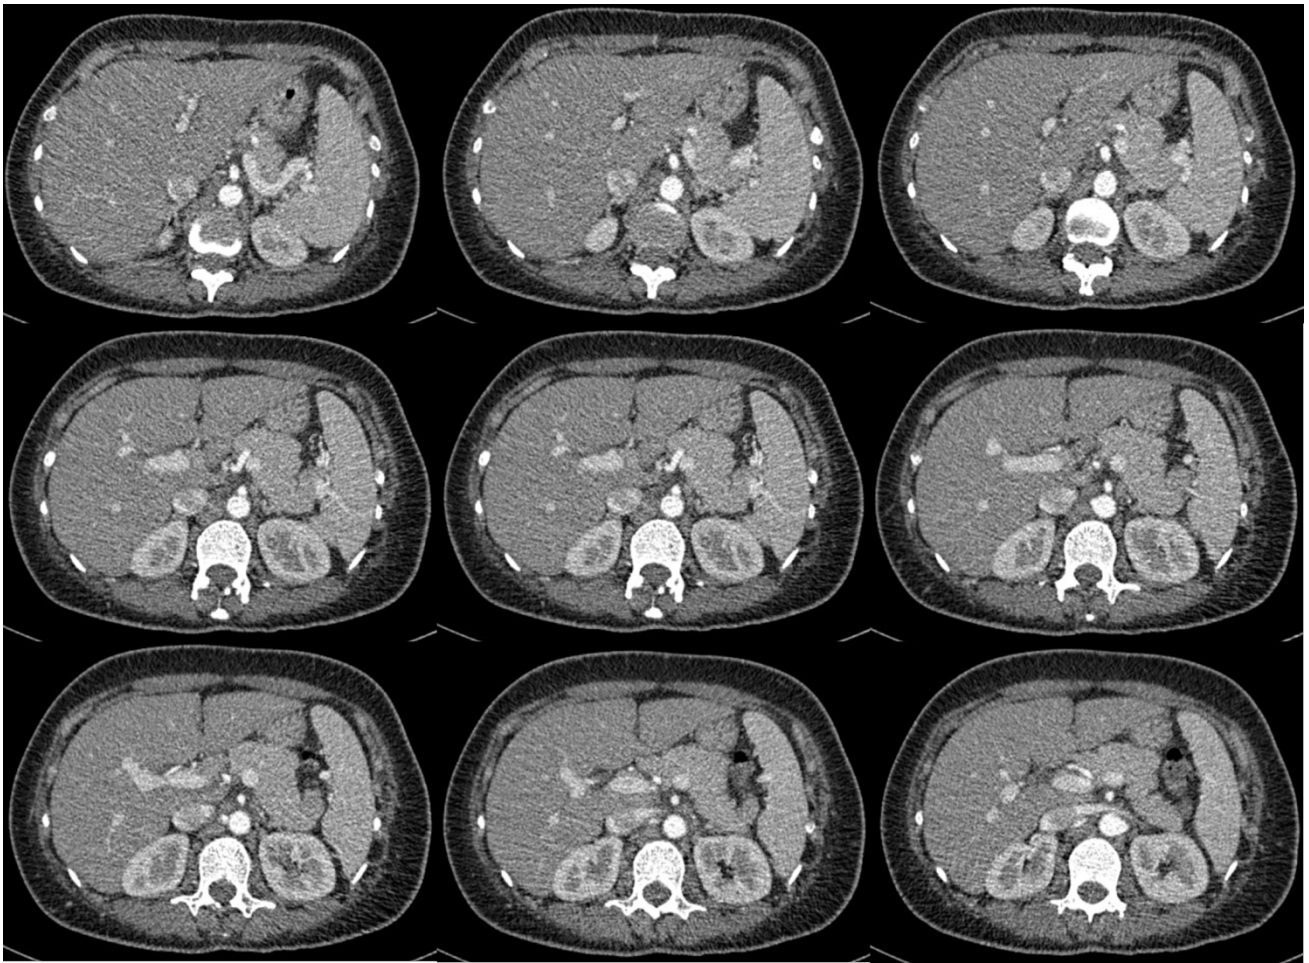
Pancreas on enhanced CT. Enhanced CT showed that the size and shape of the pancreas were normal, the edges were clear, the parenchyma density were uniform, and the pancreatic duct had no obvious expansion.
